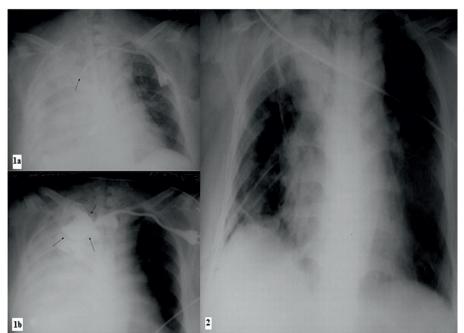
Chest X-ray pleural effusion and abnormal position of catheter (1a), contrast image in the right thorax (1b)
